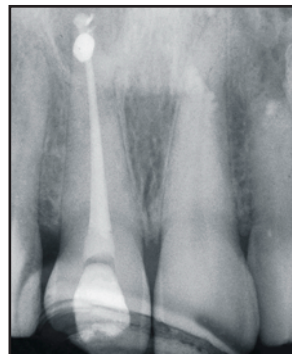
Radiograph of tooth #8 following endodontic treatment.
